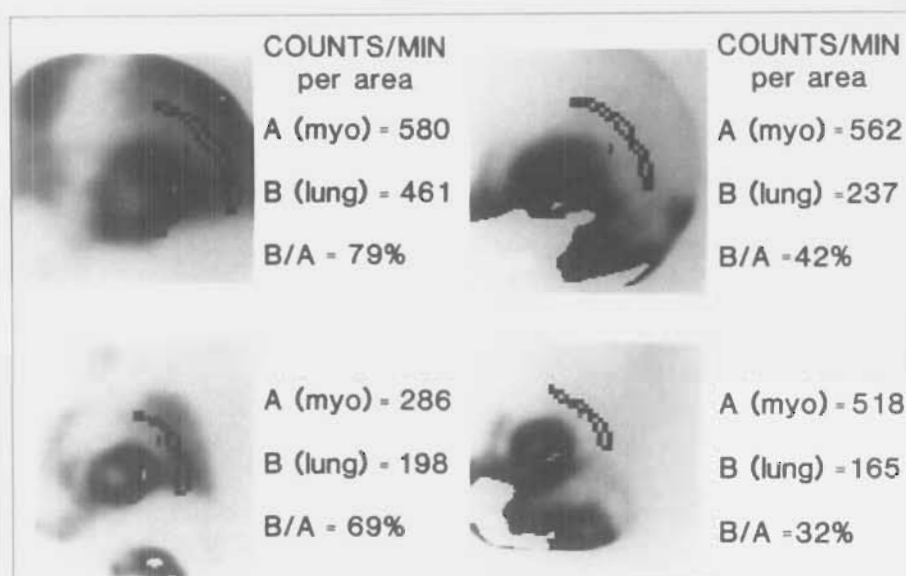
Quantitation of lung uptake of MIBI using pulmonary/myocardial ratios (P/M) in two men who had previous infarctions followed by angioplasty. Upper panels show immediate left anterior oblique 40° images and lower panels show corresponding SPECT tomographic acquisitions obtained 70 min after stress. Patient shown in left panels performed exercise to a peak heart rate of 162 bpm and had increased uptake on immediate image (P/M = 79%) and on delayed tomographic acquisition (P/M = 69%). Patient on right was stressed with dipyridamole followed by a low level of exercise limited by knee pain (arthritis) and chest pain. Because of high abdominal uptake, saturation of images was necessary to visualize the myocardium, and values were within normal range on both immediate (P/M = 42%) and delayed images (P/M = 32%).
